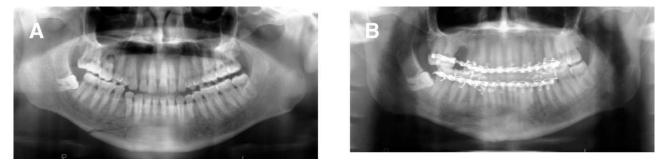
Pre-treatment (A) and 8 weeks post-treatment (B) radiographs of a patient with a comminuted right mandibular body fracture that was minimally displaced (see space between the lower right premolars) and only moderately mobile. The patient was treated closed with 5 weeks of MMF and the fracture healed uneventfully.
